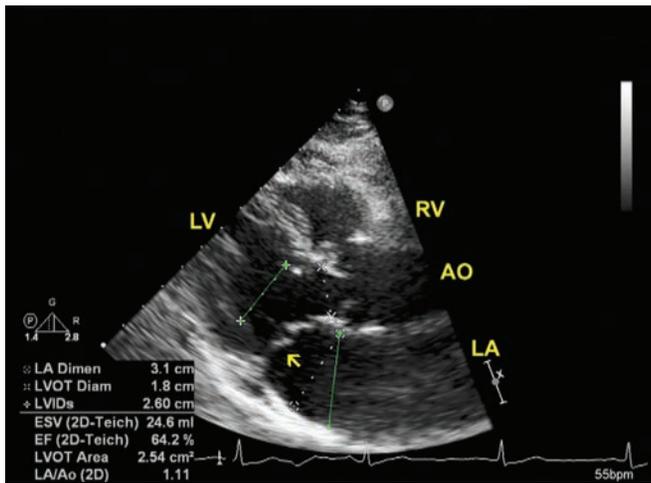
Parasternal long axis view. LA size is normal, measuring 3.1 cm.
